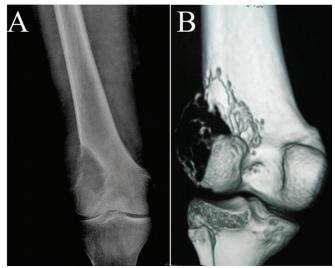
(A) Preoperative X-ray and (B) preoperative 3d CT.
